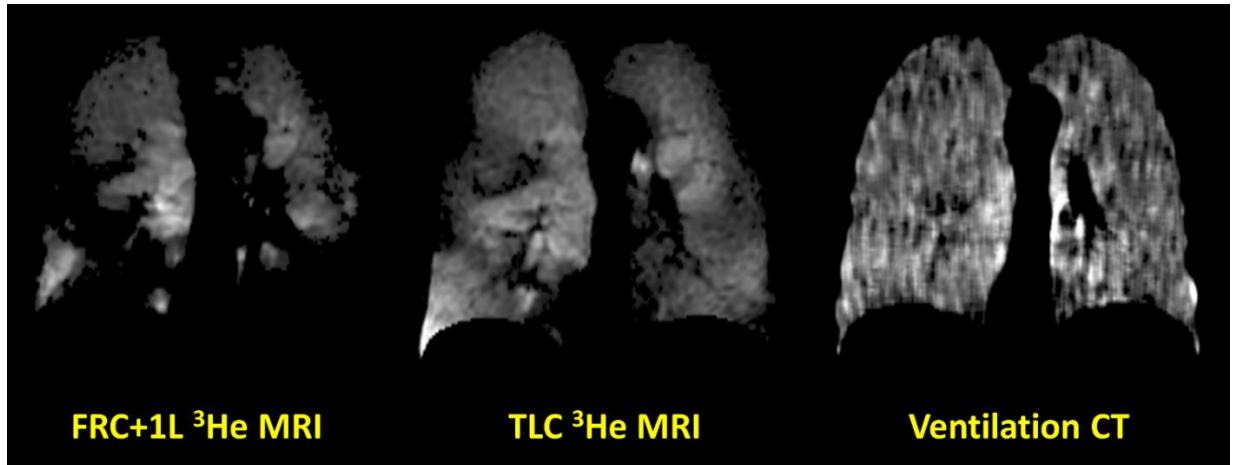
Corresponding coronal slices for a representative patient of registered FRC+1L and TLC ³He MRI and ventilation CT.
